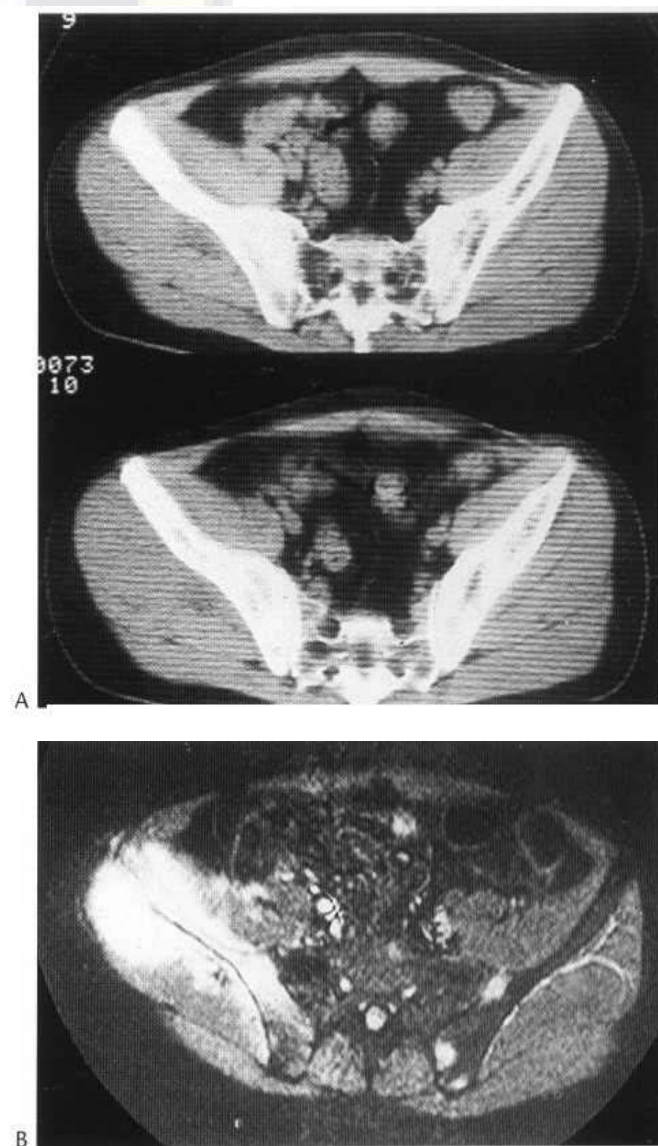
(A) CT of the pelvis in non-Hodgkin's lymphoma showing diffuse sclerosis within the right innominate bone, with ill-defined periosteal bone formation on the inner surface. A soft-tissue mass is evident. (B) The extent of these changes is easier to appreciate on the axial STIR image, where additional lesions within the left innominate bone are also evident.
